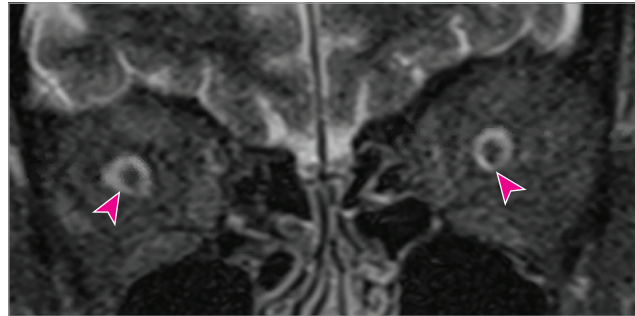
A, Macular optical coherence tomography of the right eye shows choroidal folds. B, Short-tau inversion-recovery (STIR) sequence magnetic resonance imaging (MRI) of the orbit in the coronal view uses fat-suppression techniques and demonstrates normal appearance of the optic nerves but enlarged optic sheaths with patulous subarachnoid space (arrowheads).
